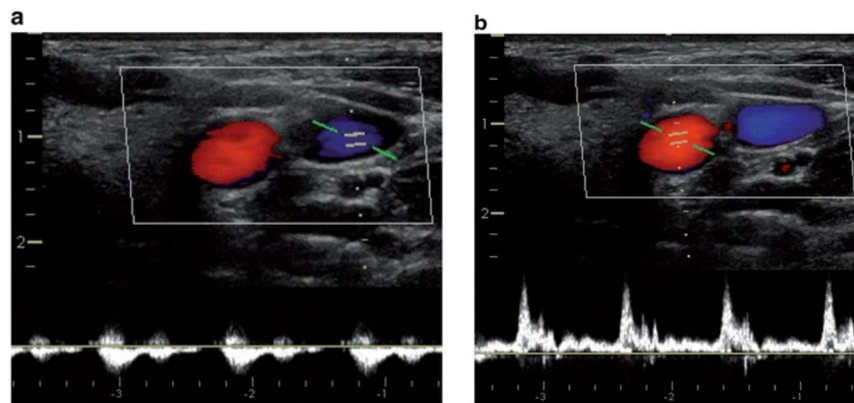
Colour Doppler imaging and flow measurements of the (a) veins and (b) arteries [36]. (Modified with permission)
